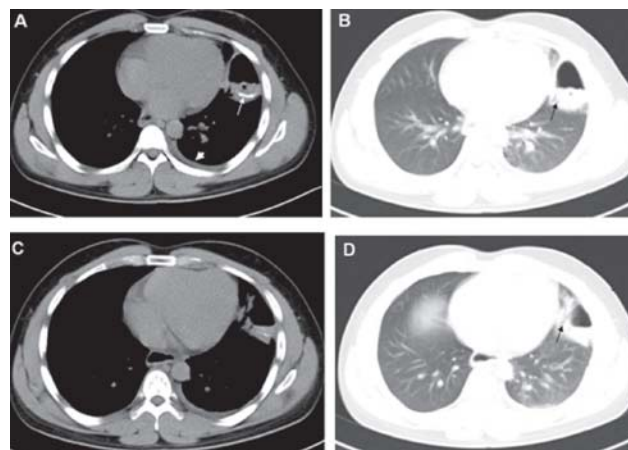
Non-contrast computed tomography of chest (A, C) (medisastinal window), showing a thin-walled cystic lesion with air-fluid level in the lingular segment of the left upper lobe. Left-sided pleural effusion (arrow head) and focal calcification in the posterior wall (white arrow) are also seen and (B, D) (lung window) showing consolidation in the adjacent lung parenchyma (black arrow).
